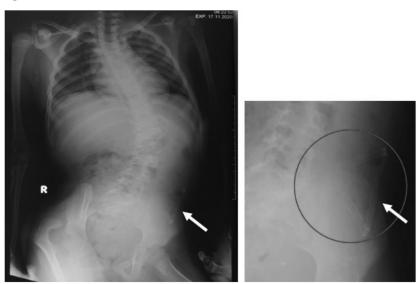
Thoracoabdominal x-ray showed no shunt tube along the shunt track, shunt fragments in the peritoneal cavity of the left iliac region (white arrow).
